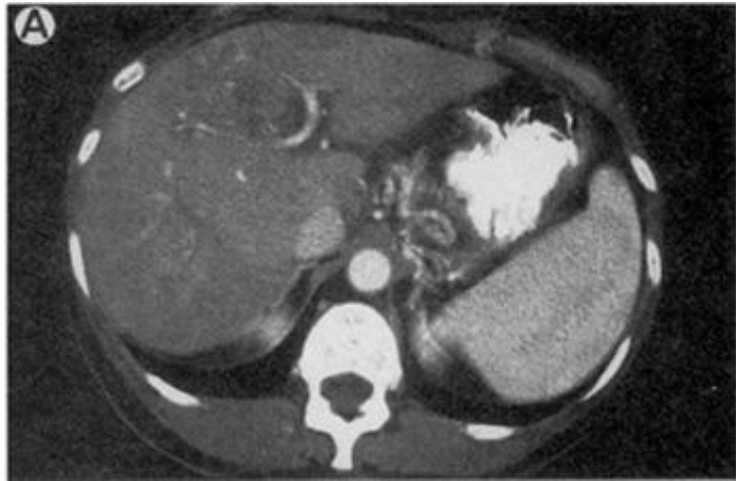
CT scan showing liver metastasis
